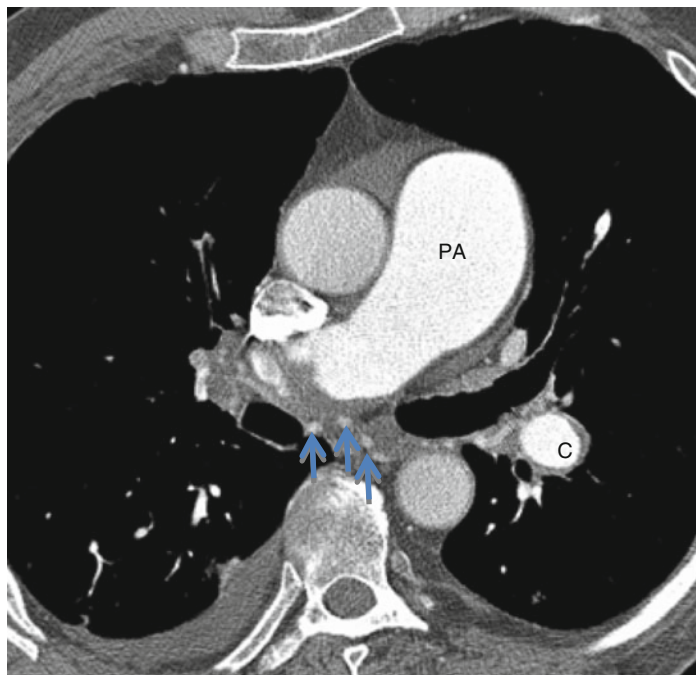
CT pulmonary angiogram showing bronchial artery hypertrophy (*arrows*) in a patient with chronic thromboembolic pulmonary hypertension. Note the marked enlargement of the pulmonary artery (*PA*) and the rim of clot around the left lower lobe pulmonary artery (*C*)
